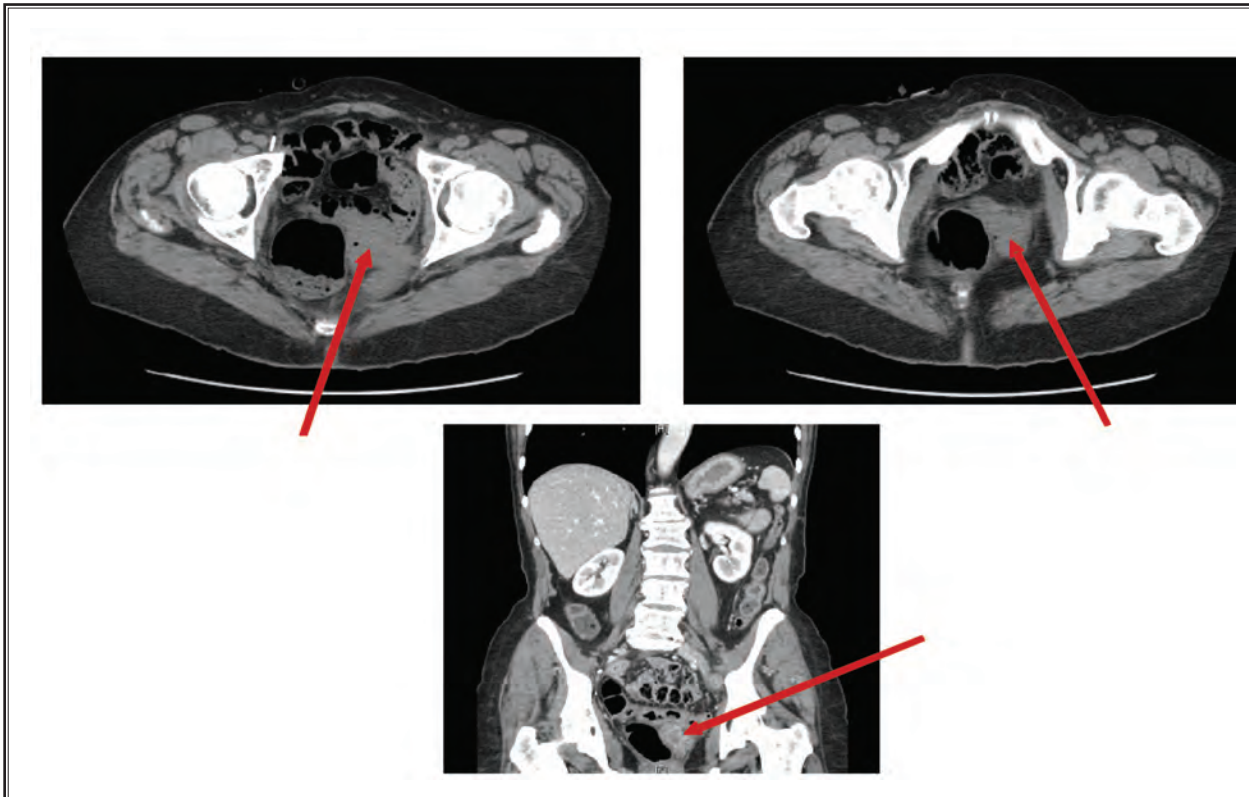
May 2006 CT scan of abdomen and pelvis showing large soft tissue densities in the left pelvis causing mass effect of the rectum (tumor indicated with red arrows).
